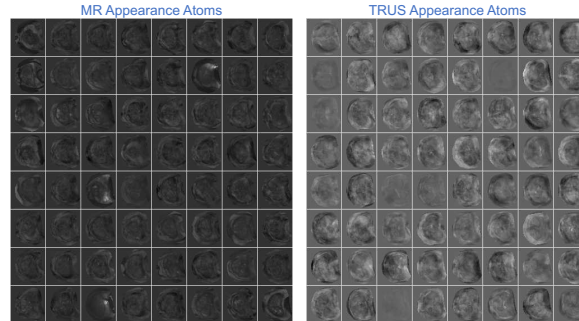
Sample dictionary atoms showing joint MRI-TRUS intensity appearance found using K-SVD. The joint eigenvector is the concatenation of the MRI eigenvector and the TRUS eigenvector at the same positions in the two corresponding matrices.
